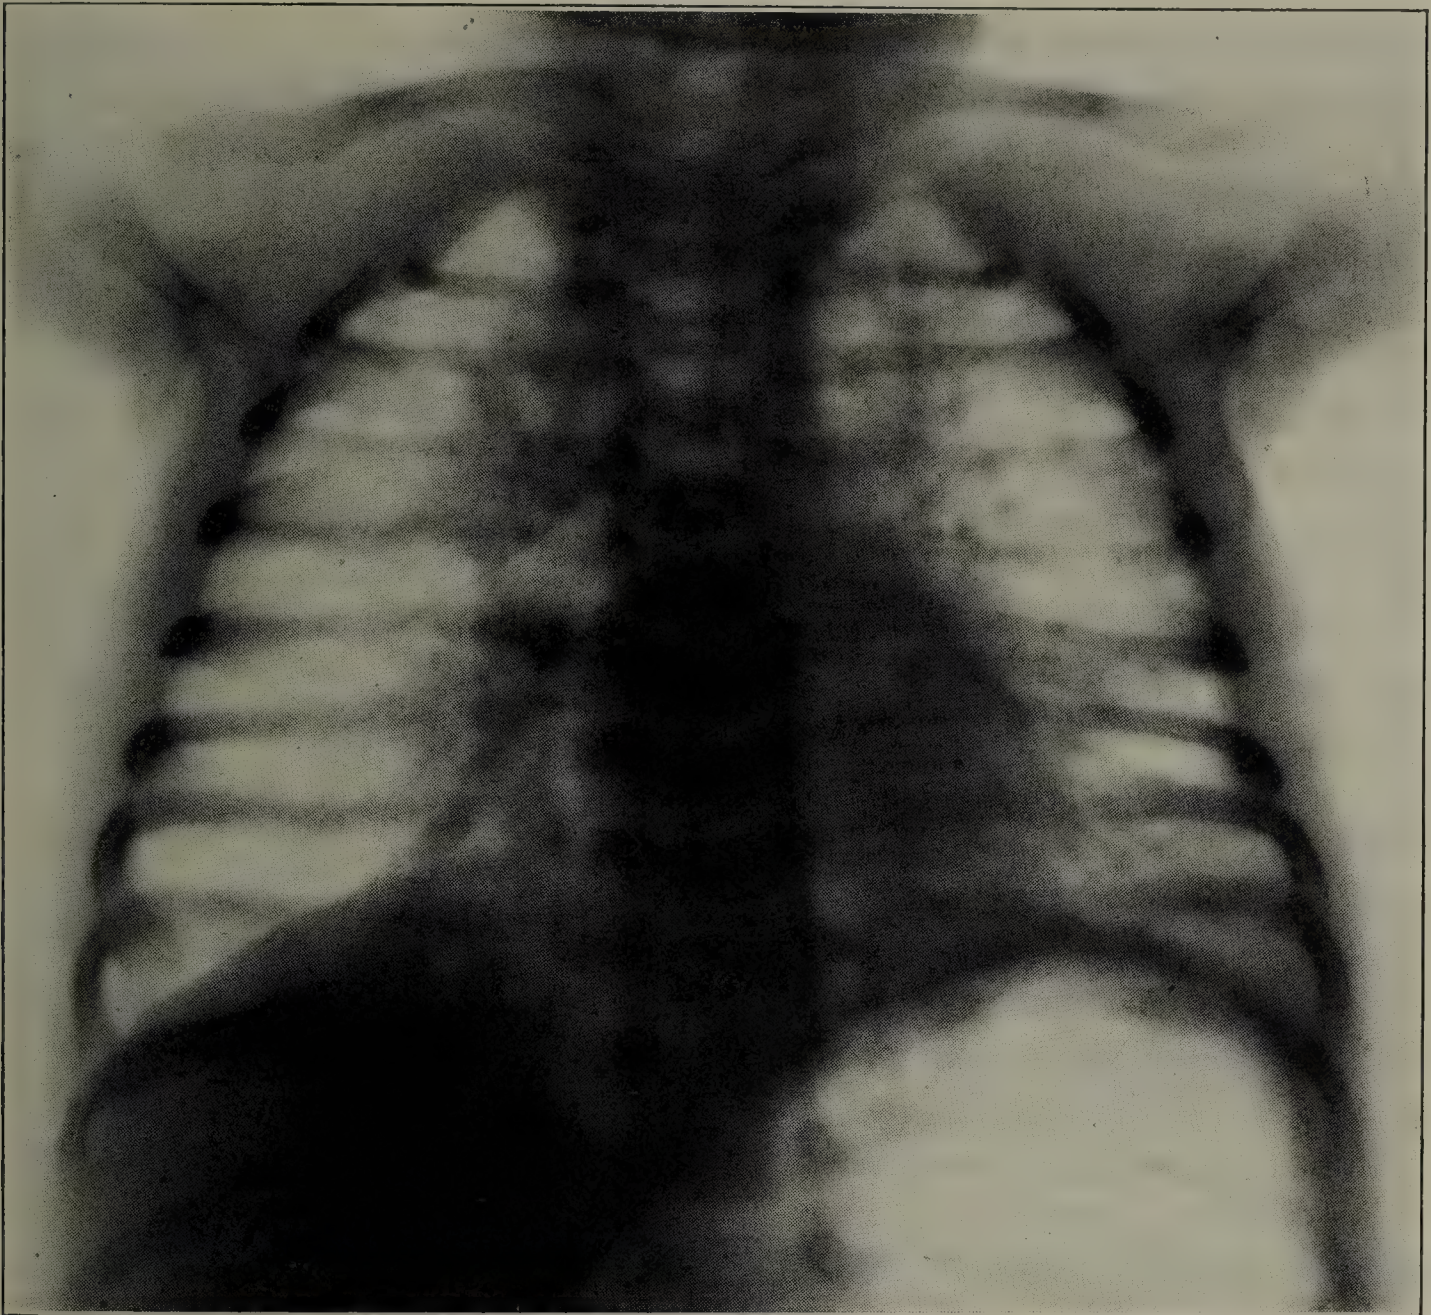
ROENTGENOGRAM IN LOBULAR PNEUMONIA, SHOWING AN INCREASE IN BRONCHOVASCULAR MARKINGS AND PATCHY AREAS OF INCREASED DENSITY IN THE MEDIAL PORTION OF THE PULMONARY FIELDS.
